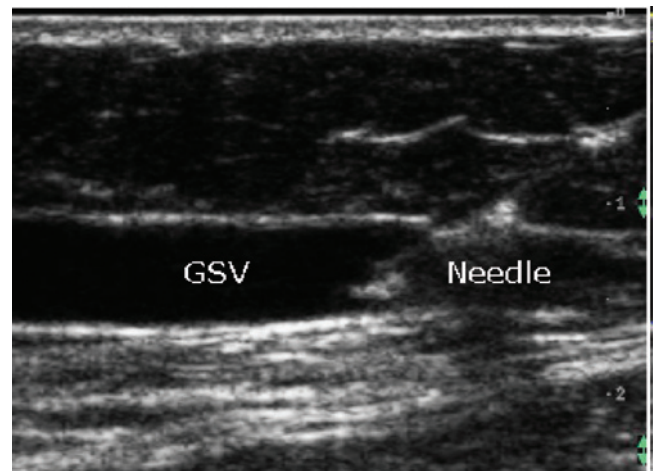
The Great Saphenous vein is cannulated using the Seldinger technique. The puncturing needle is echogenic and can be easily visualized. (Adapted from Pichot O, Atlas of Ultrasound Images, Copyright VNUS® Closure)
